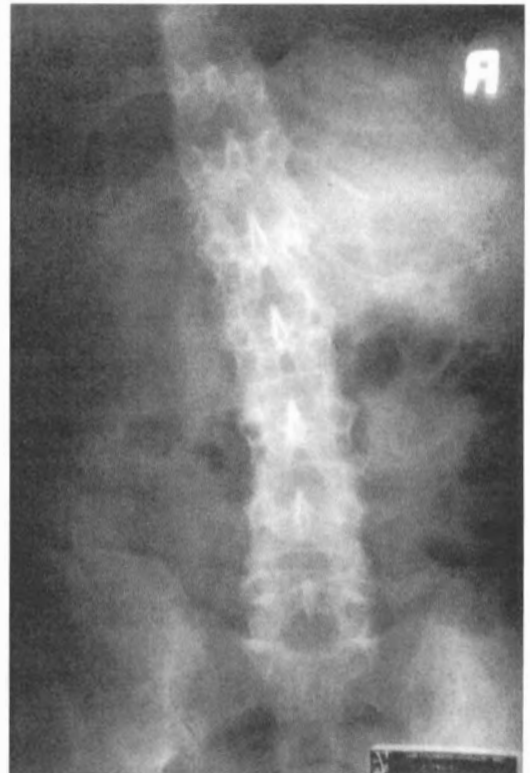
is a picture of this patient standing upright, and Figure 10.163 is a PA radiograph showing the left antalgia of the thoracolumbar spine. When first seen, this patient was walking with a walker.
